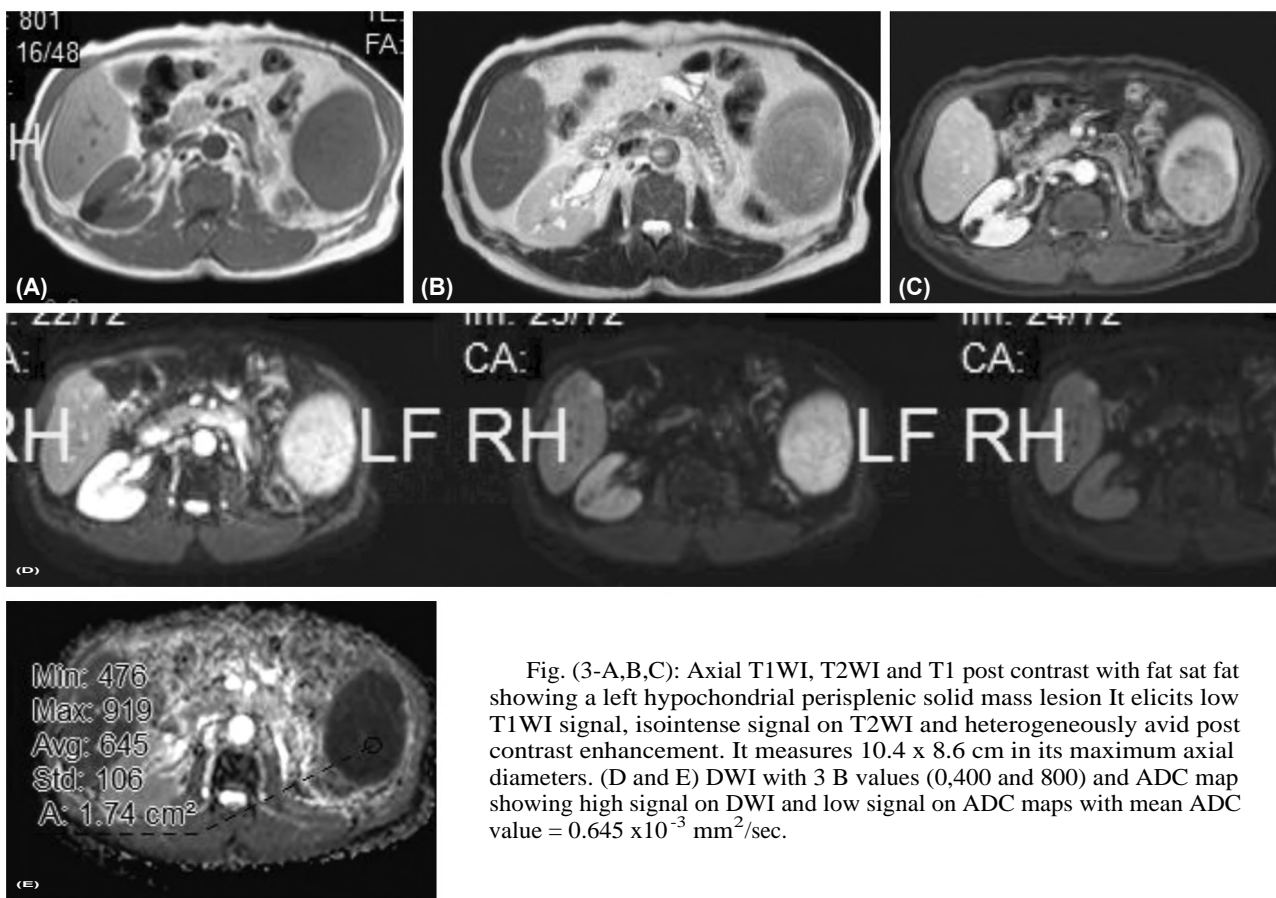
Axial T1WI, T2WI and T1 post contrast with fat sat fat showing a left hypochondrial perisplenic solid mass lesion. It elicits low T1WI signal, isointense signal on T2WI and heterogeneously avid post contrast enhancement. It measures 10.4 x 8.6 cm in its maximum axial diameters. (D and E) DWI with 3 B values (0,400 and 800) and ADC map showing high signal on DWI and low signal on ADC maps with mean ADC value = 0.645 x10⁻³ mm²/sec.
